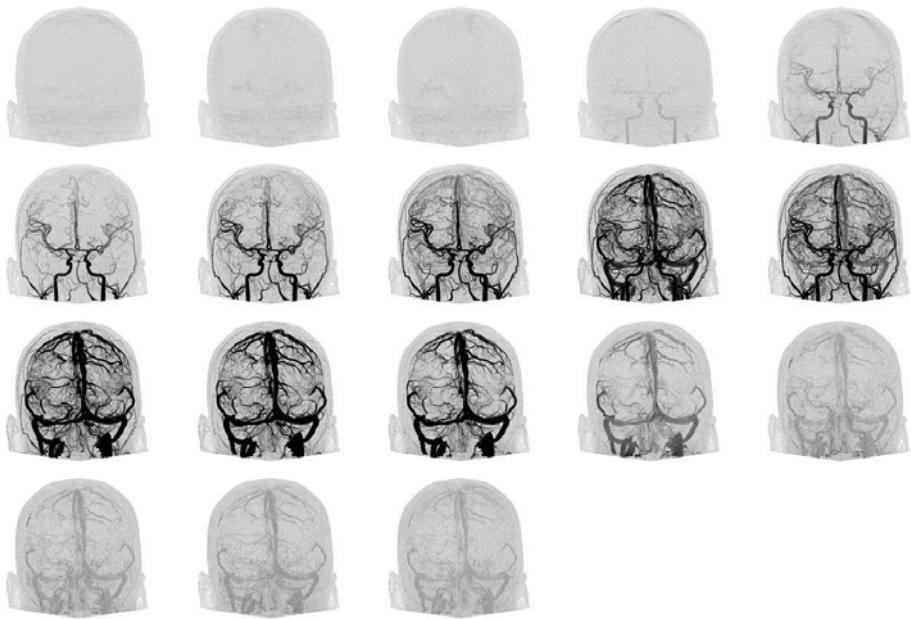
A dynamic CT angiography study of the brain with a volumetric CT scanner that covers the entire brain (Aquilion ONE, Toshiba).
